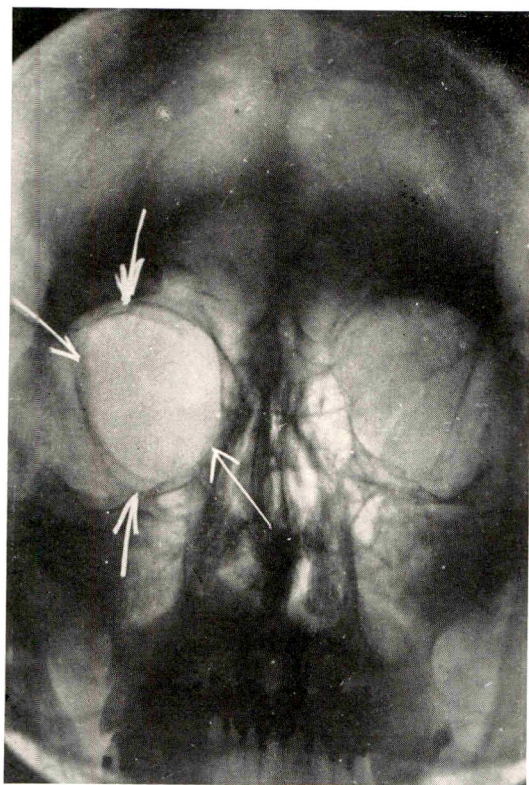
Roentgenogram of a case which Dr. M. J. Hubeny has been good enough to send me and which shows the absence of the superior and posterior orbital wall as indicated by the arrows.
